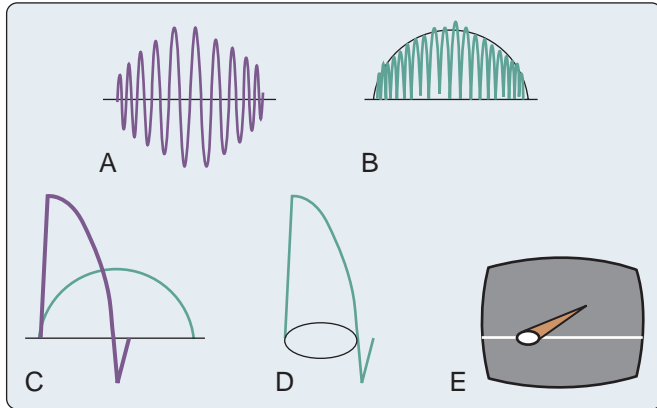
Leading-edge enhancement techniques. (A) Radio-frequency (RF) type of echocardiographic display. (B) This video represents the average height of the upper half of the RF signal. (C) Differentiation is obtained by taking the first derivative of the video display. (D, E), Intensity modulation represents the conversion of signal amplitude to intensity, changing the signal from a spike to a dot. (From Thys DM, Hillel Z. *How it works: basic concepts in echocardiography*. In: Bruijn NP, Clements F, eds. *Intraoperative Use of Echocardiography*. Philadelphia: JB Lippincott; 1991:255–318.)
